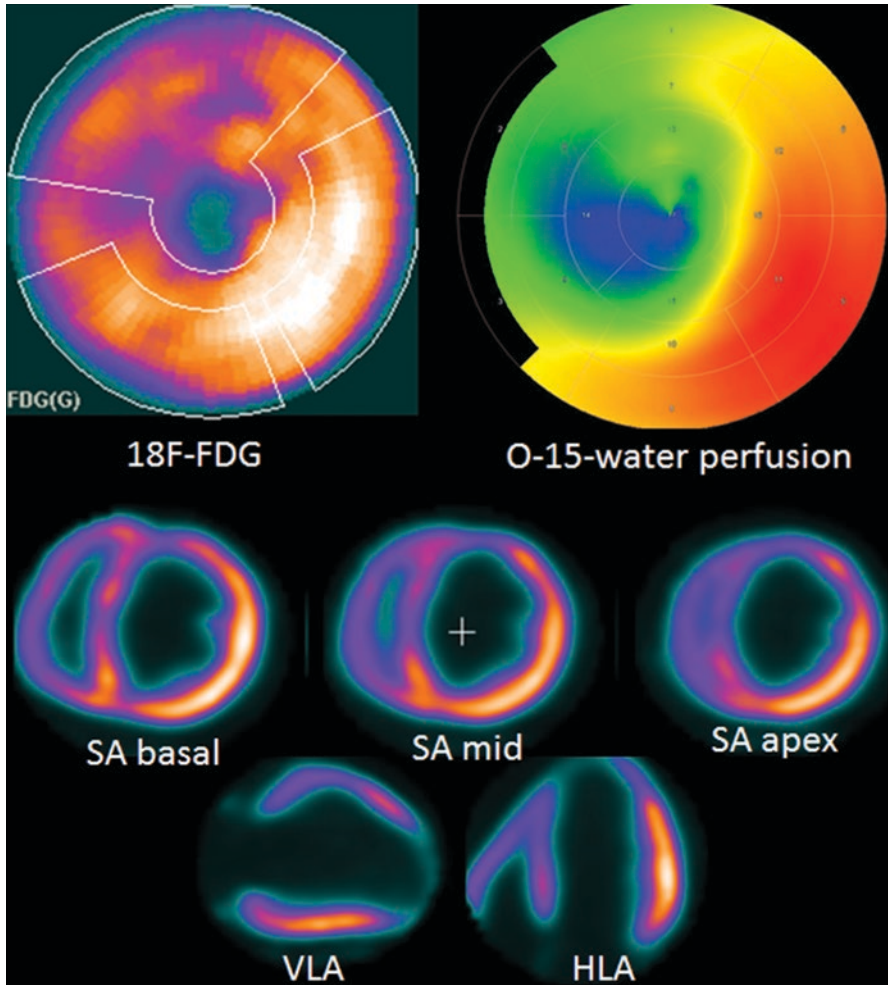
Myocardial viability study using ^{18}F -FDG and resting myocardial perfusion study using ^{15}O -water. The patient had 3-vessel obstructive coronary artery disease, contractile dysfunction in the territory of the LAD coronary artery, reduced left ventricle ejection fraction (35%), and high surgical risk. Resting perfusion is reduced in the LAD territory. Viability study shows absence of ^{18}F -FDG uptake in the apex, but partially preserved uptake elsewhere in the LAD territory indicating partially preserved viability. SA short axis, ^{18}F -FDG ^{18}F -fluorodeoxyglucose, HLA horizontal long axis, LAD left anterior descending, VLA vertical long axis
